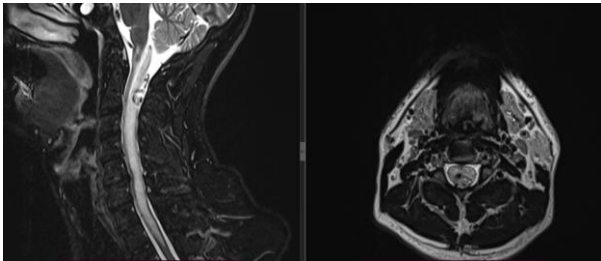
Cervical spine MRI - intramedullary subdural tumour at the C2 level with medullary infiltration.
